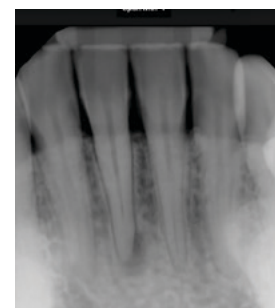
Tooth #25: Necrotic pulp/asymptomatic apical periodontitis, periapical radiolucency
